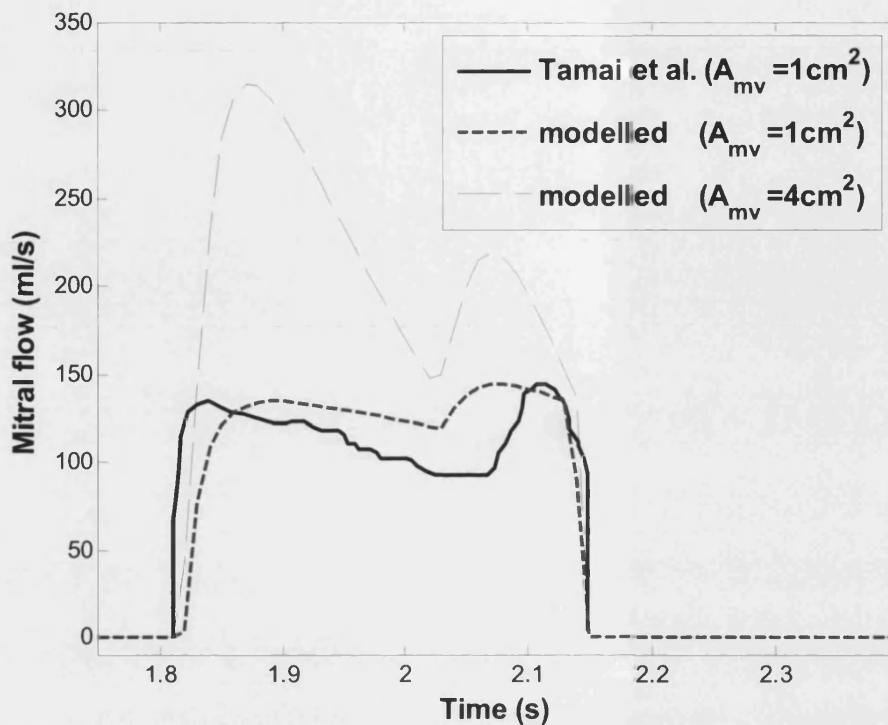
Model generated mitral flow in healthy person and patients with mitral stenosis compared to doppler recordings of transmitral flow from Tamai et al. (1990)
